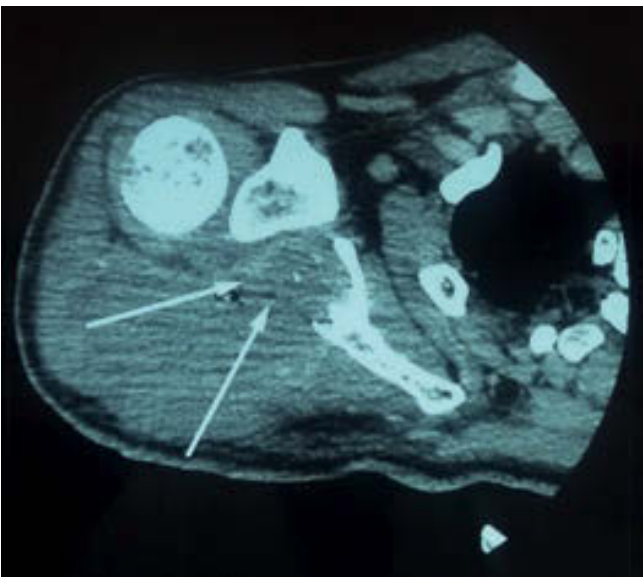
The right-shoulder CT scan: tumor infiltration in the soft tissues of the acromioclavicular joint.
